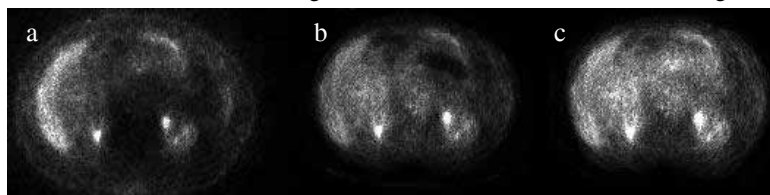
Examples of PET images (a) Non-Attenuation Corrected; (b) Attenuation Corrected from CT; (c) Attenuation Corrected from MRI
